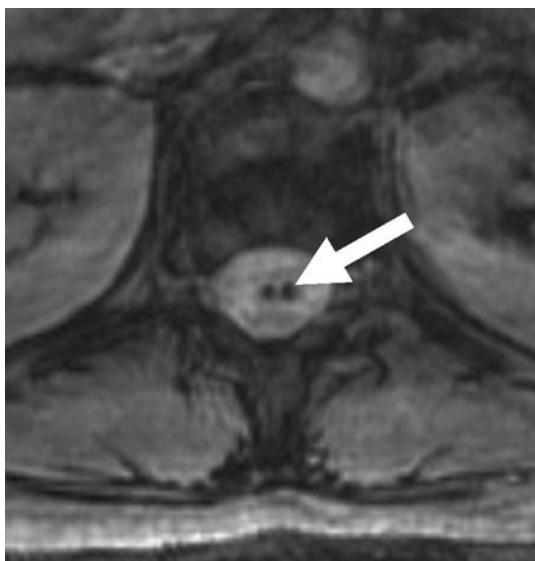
Gradient-echo sequence MRI performed 16 h after the beginning of the weakness revealed small petechia in the conus medullaris (arrow)
